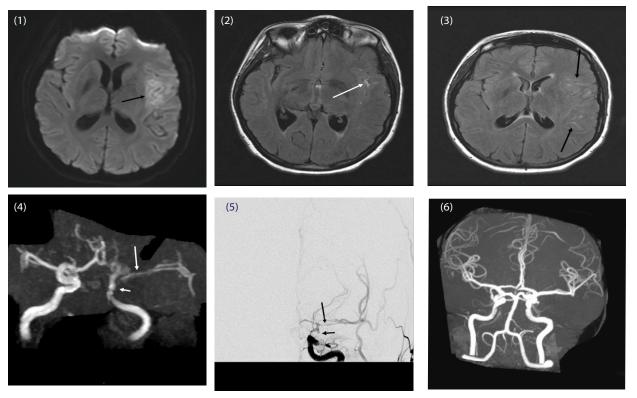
Diffusion weighted imaging (DWI) shows hyperintensity indicative of core infarction on MRI within less than 3 h after onset.
